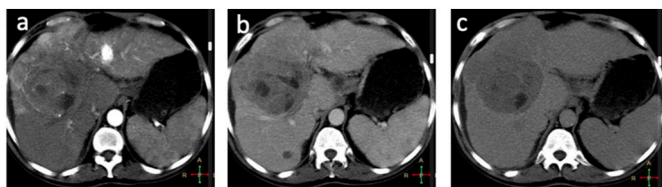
CT of metastatic malignancy a) arterial phase b) portal venous phase c) delayed phase. Case courtesy of Dr. Ahmed Abdrabou, [Radiopaedia.org](https://radiopaedia.org/cases/22888), rID: 22888. <https://radiopaedia.org/cases/22888>.
